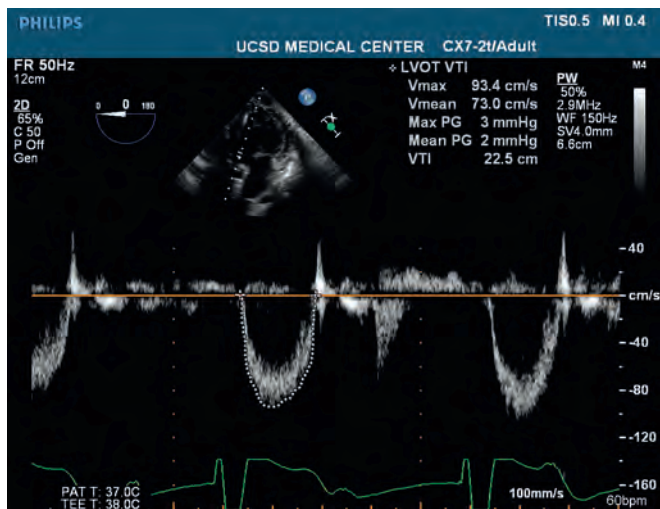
Left ventricular outflow tract (LVOT) velocity waveforms obtained in the echocardiographic deep transgastric view. FR, Frequency; PG, pressure gradient; PW, pulsed-wave; Vmax, maximum velocity; Vmean, mean velocity; VTI, velocity-time integral. (Courtesy University of California San Diego, La Jolla, Calif.)
